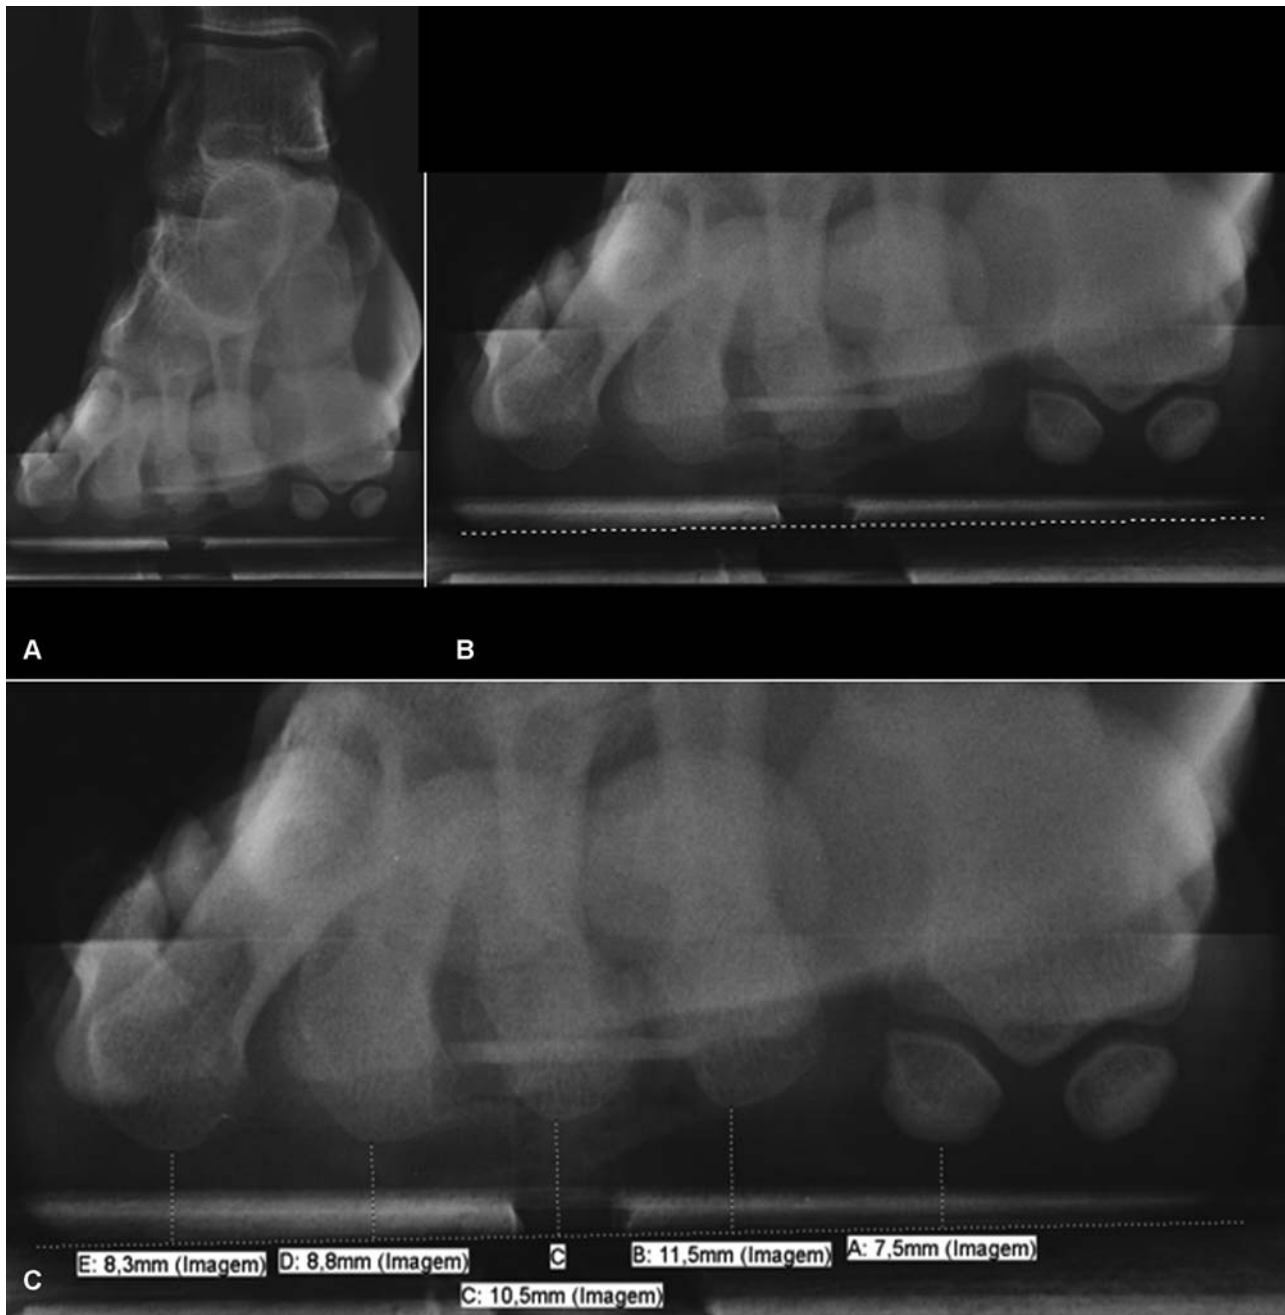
Visual aspect of axial radiography with forefoot load. (A) image obtained allowing the visualization of all forefoot; (B) line of support drawn, marking the plane of the forefoot load; (C) from the most plantar points of the five rays we measure the distance to the line.
